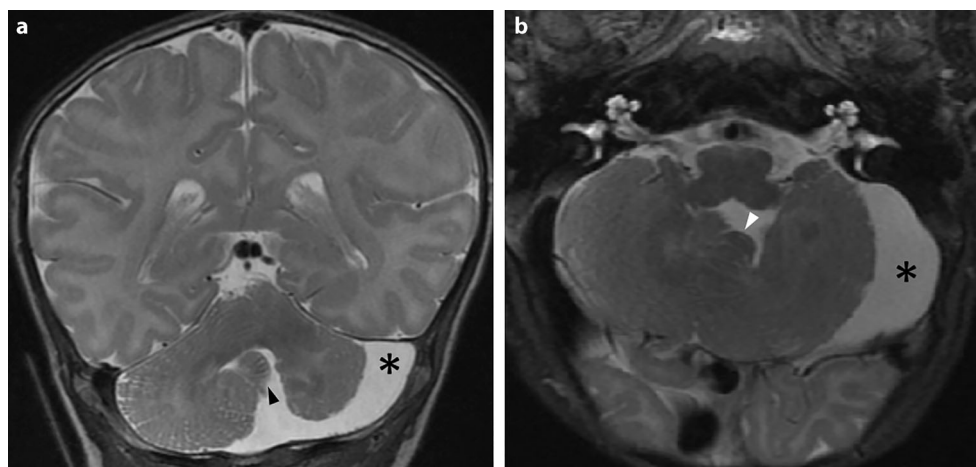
a, b Coronal (a) and axial (b) T2-weighted fast spin-echo (FSE) images of the brain in a 3-week-old patient depicting an abnormal vermian (arrowheads) and left-sided cerebellar hypoplasia with pronounced cerebrospinal fluid (CSF) space (asterisks). The cerebellum is dysplastic with cortical anomaly and areas of heterotopia throughout the cerebellar white matter. Associated ipsilateral hemangioma of the head and absence of the internal carotid artery are not shown. This constellation is characteristic for PHACE association
